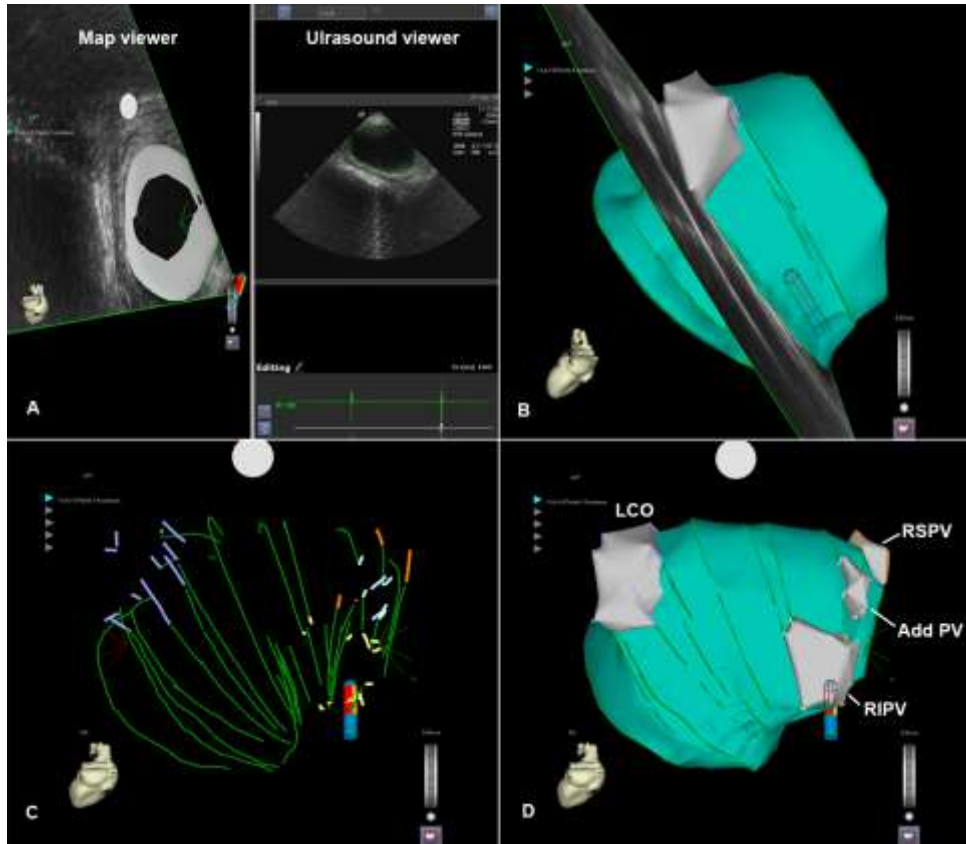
Three-dimensional (3D) mapping with intracardiac echocardiographic (ICE). Ultrasound images of the left atrium (LA) are acquired. The endocardial contour of the LA is traced on the ultrasound viewer of the mapping system. After assigning the contour to a map, it appears on the map viewer (A). By acquiring more contours and reconstructing them into a registered 3D shell (B), the shape of the LA and pulmonary veins (PVs) is depicted. Systematically, the LA and PVs are visualized (C) until a complete 3D map of the LA and PVs is acquired (D). Add PV = additional pulmonary vein, LCO = left common ostium, RIPV = right inferior pulmonary vein, RSPV = right superior pulmonary vein.
